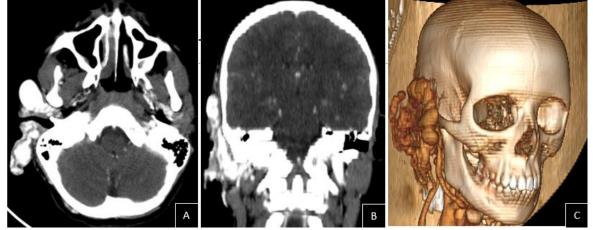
Facial CT scan with contrast: axial (A), coronal (B) and in 3D reconstruction (C): Thickening of the right pinna extending into the external auditory canal with individualization of several serpiginous vascular structures within it after injection of contrast agent
